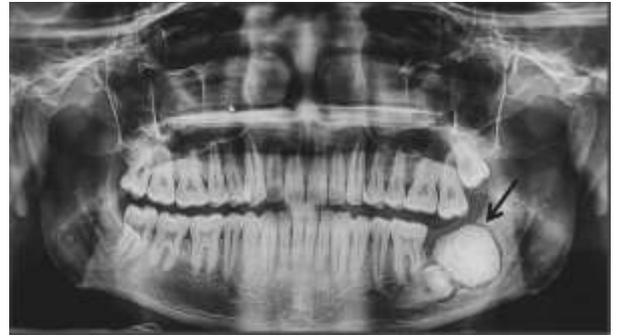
Panoramic radiograph showed a rounded radiopacity, in association with unerupted left mandibular second molar. The dense radiopaque area was amorphous, and circumscribed by a thin, irregular radiolucent boundary
